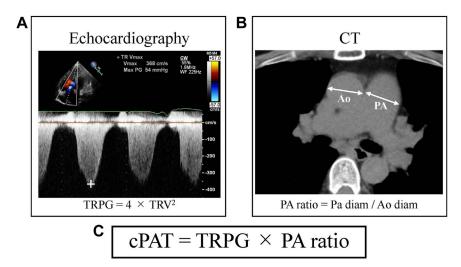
Measurement of 3 parameters. (A) Combined two indexes: tricuspid regurgitation pressure gradient (TRPG) was calculated using modified Bernoulli's principle. (B) Pulmonary artery (PA) ratio was calculated as the ratio of the widest main pulmonary artery diameter (PA-diam) and an adjacent ascending aorta diameter (Ao-diam) at the same level of bifurcation of the main pulmonary artery. (C) The combination of TRPG and PA ratio was named cPAT, for combination index of the TRPG and the PA ratio, measured by computed tomography (CT). TRV, tricuspid regurgitation velocity.
